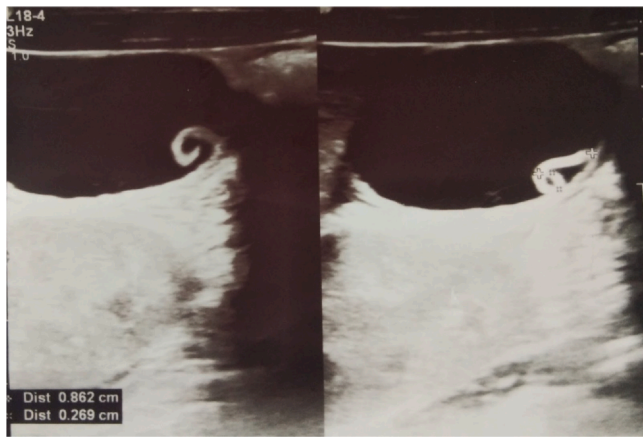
Ultrasound scan shows a motile tubular structure suggestive of ascaris in gall bladder.
